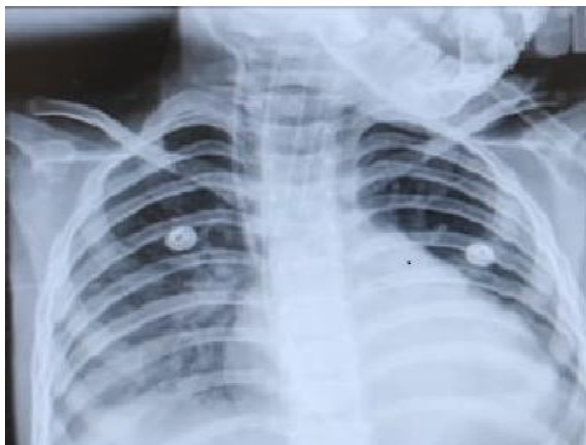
The chest X-ray shows bilateral pleural effusion with interstitial infiltration.
